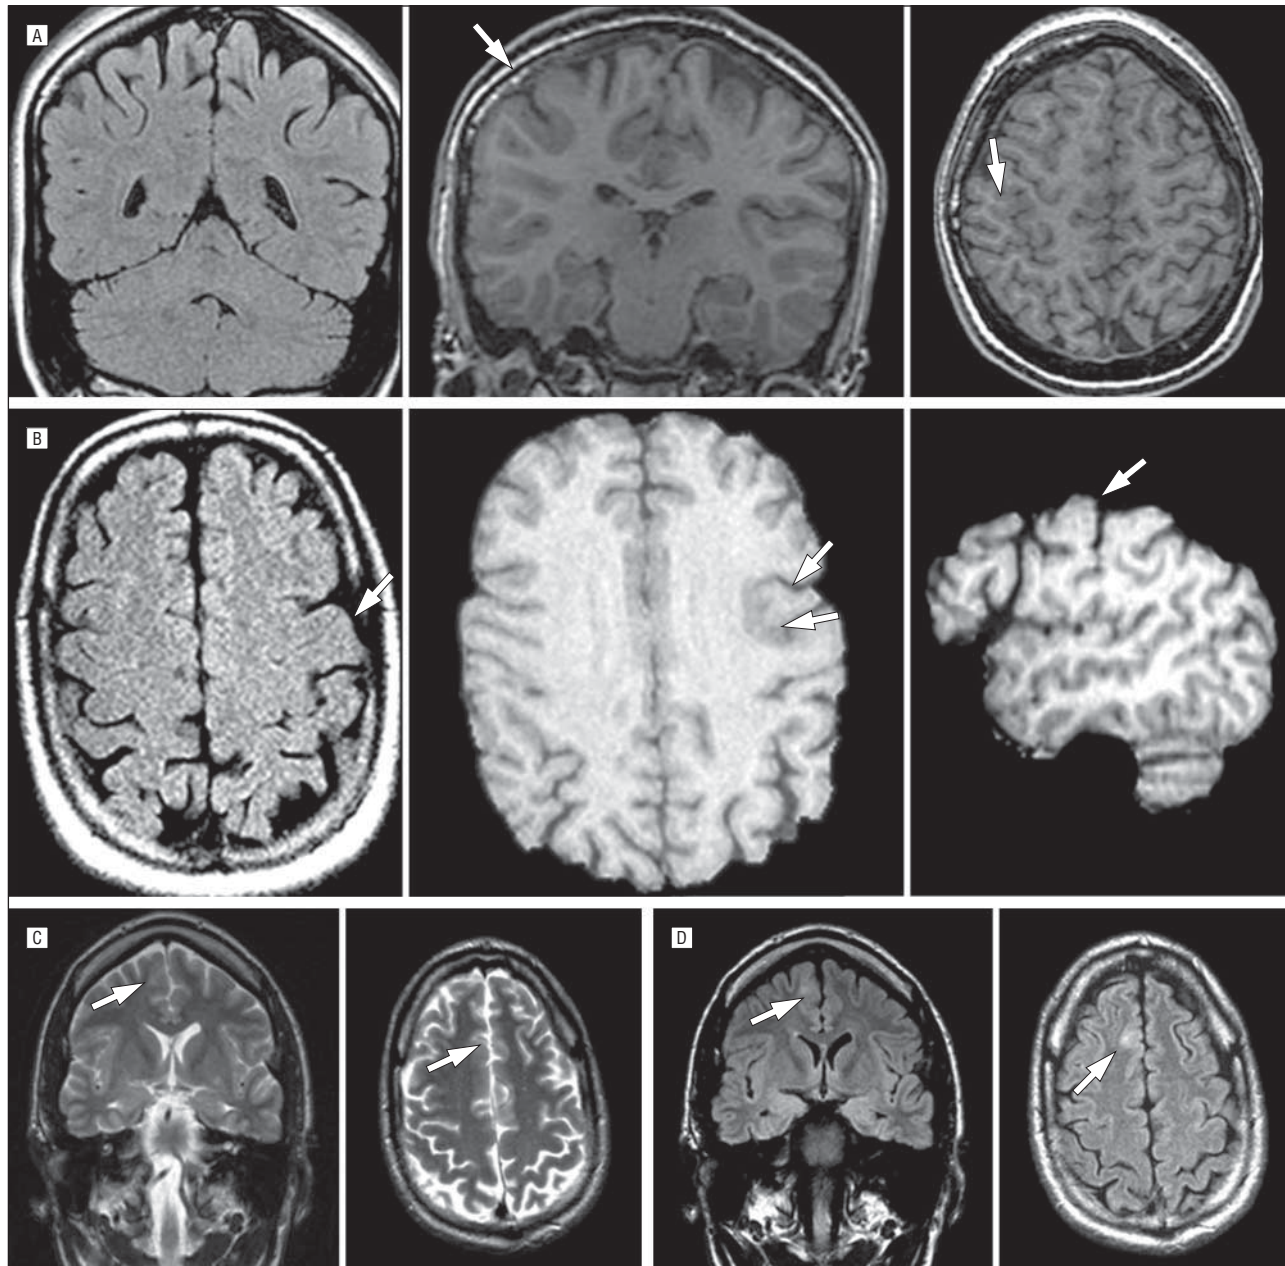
Selected magnetic resonance imaging (MRI) panels. A, The left panel is a coronal flair section and the middle panel is a coronal T1-weighted MRI. Note the subtle thickened cortical gyrus. This patient's MRI was deemed normal by outside evaluations. The right panel is an axial T1 MRI showing a subtle and thickened cortical gyral pattern (arrow). B, Axial flair, axial gradient echo, and sagittal gradient echo images identify cortical abnormalities ultimately consistent with focal cortical dysplasia and cure postresection. The left panel is an MRI that was deemed normal at an outside institution, and the middle and right panels were done as follow-up studies because of our clinical suspicions. C, The left panel is a T2 coronal section and the right panel is a T2 axial image. D, The left panel is a flair coronal section and the right panel is a fluid-attenuated inversion recovery axial image. Arrows in parts B-D denote the focal cortical dysplasia that was ultimately resected on neuroimaging and initially deemed normal at outside institutions.
